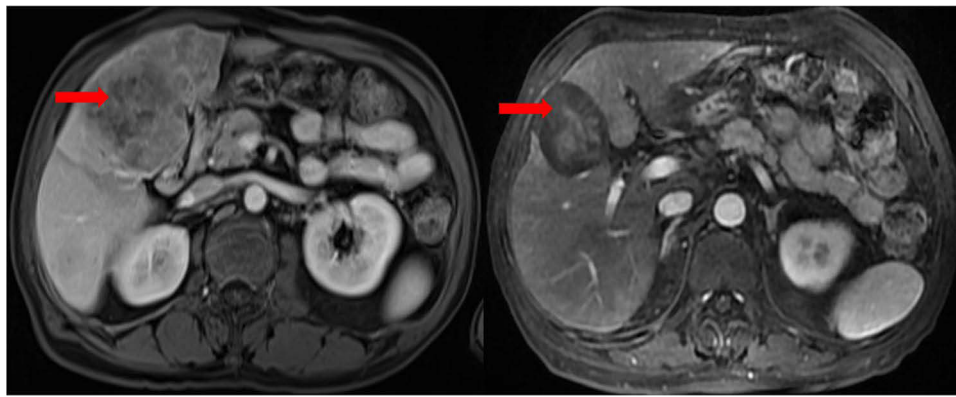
CT scan results of the changes for target lesions in the liver site of the CR patient with HCC before and after the administration of TACE combined with Lenvatinib and Sintilimab (Red arrows represent the location of target lesions).
